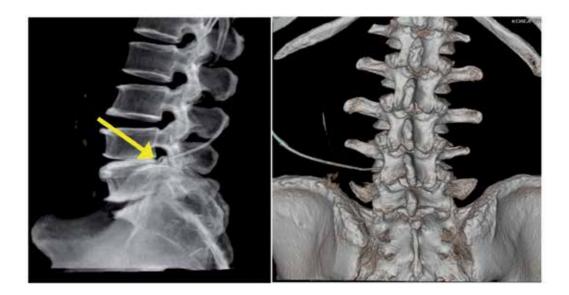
A three-dimension computed tomographic reconstruction image of the pathway of the L'DISQ wand is shown. In this case, the introducer needle was advanced posterior to the annulus into the annular extrusion. The tip of the L'DISQ wand (yellow arrow) is seen within the extrusion disc. The computed tomography scan was obtained with the patient's permission to evaluate immediate post procedure changes.
